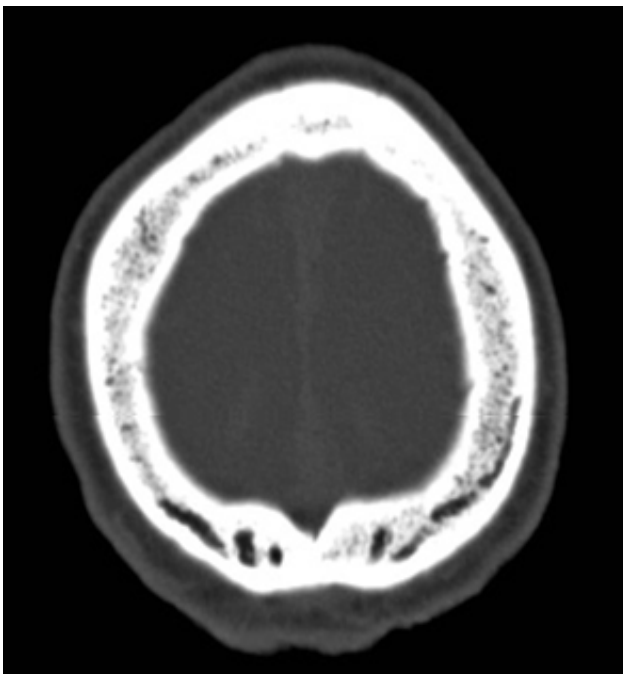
Skull CT, bone window. Linear and serpiginous vascular images (diploic veins)
